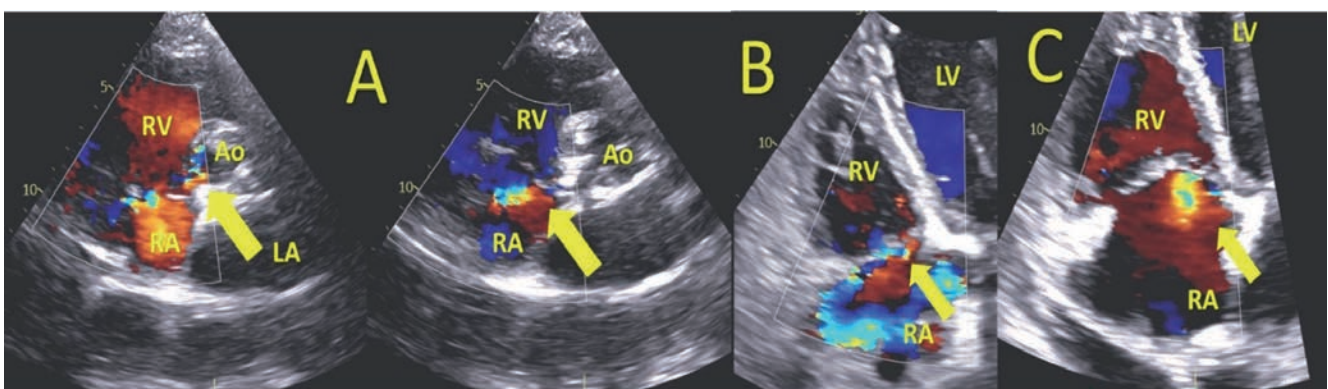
A) Parasternal short axis in transthoracic echocardiogram (TTE): strange turbulent flow from the aorta to the right atrium; B,C) A4C in TTE: turbulent sisto-diastolic flow directed into the right atrium, mixed with the jet of tricuspid insufficiency. Ao, aorta; LV, left ventricle; RV, right ventricle; RA, right atrium.
